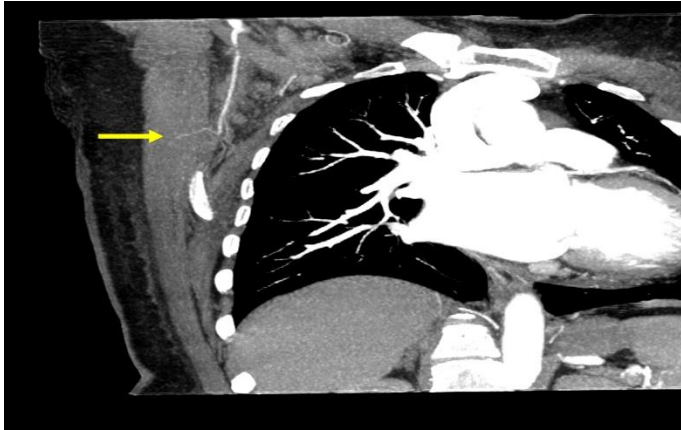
Computed tomographic angiography (CTA) showing one of the perforators of the descending branch of the Thoracodorsal artery (yellow arrow) in coronal view
